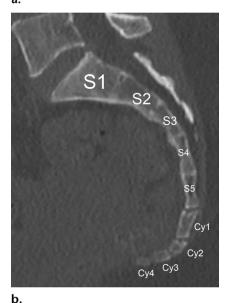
Normal sacral and coccygeal anatomy. Lateral radiograph (a) and midline sagittal CT image (b) of the sacrum and coccyx show the normal five sacral and four coccygeal segments.
